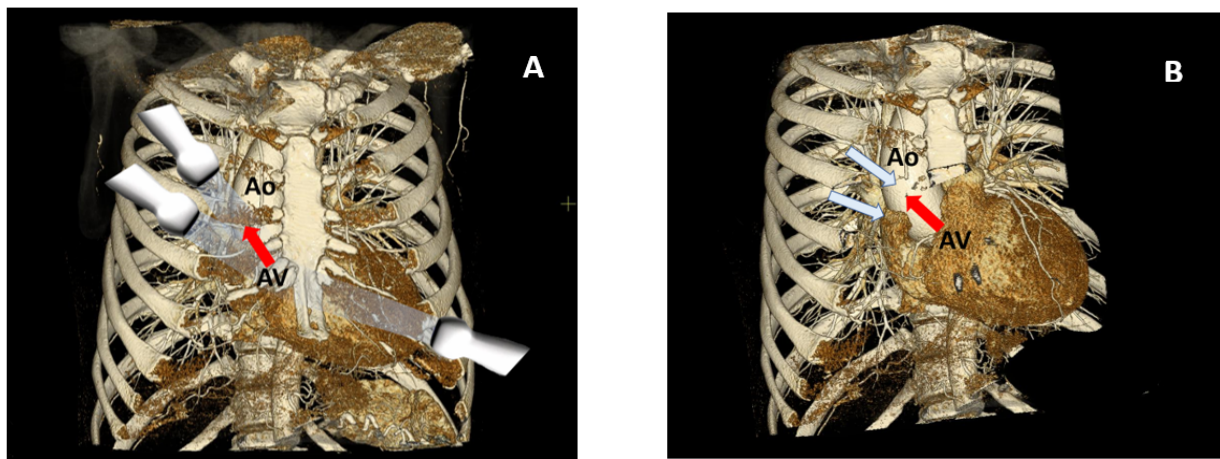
Doppler transaortic flow intercept. (A) Apical and right-parasternal positioning of the sector ultrasound transducer, (B) facing direction of the ultrasound beam plane in relation to the transaortic flow (marked by a red arrow). The aortic valve (AV) and ascending aorta (Ao) are registered.
